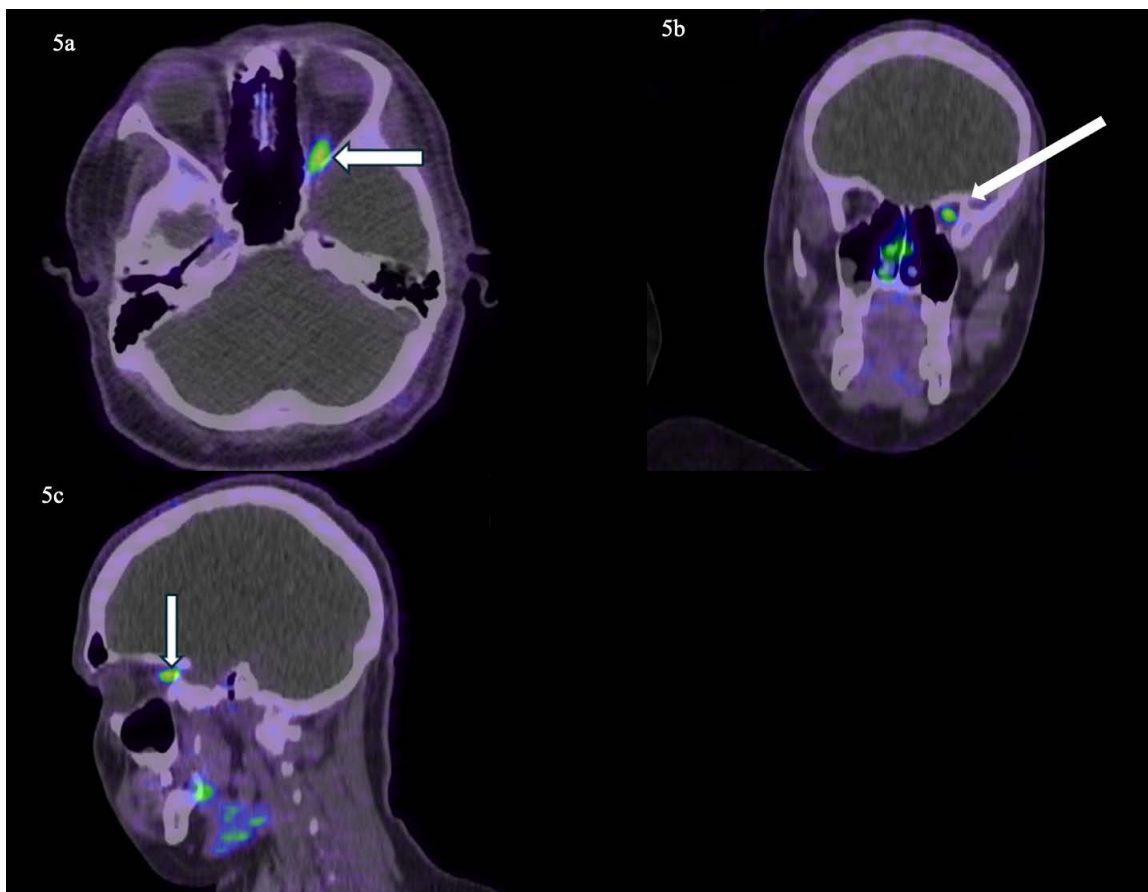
Ga-68 DOTATATE PET/CT (a. Axial view, b. Coronal view, c. Sagittal view)
